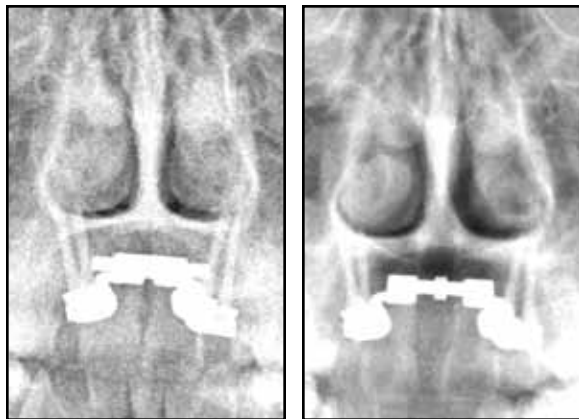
Case 1. Posteroanterior radiographs of maxilla before and after suture opening show unchanged inclination of miniscrews, dehiscence of midpalatal suture, and significant enlargement of nasal cavity.
